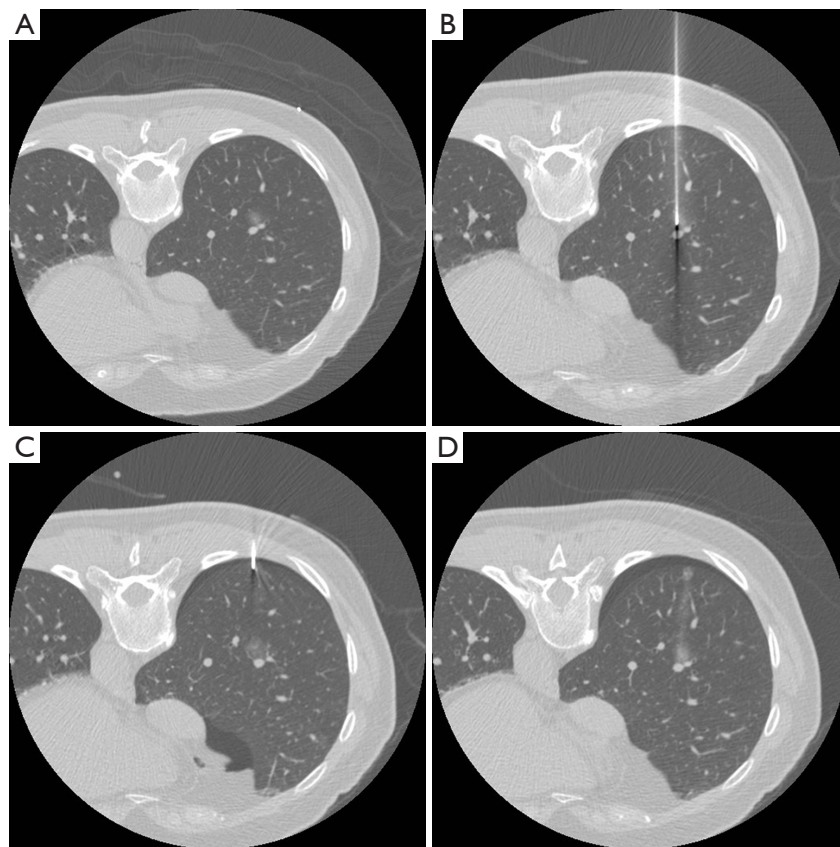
Computed tomography (CT) images of localization. (A) The patient was in supine position, and one small nodule was noted in the right lower lobe; (B) deep marks; (C) superficial marks with mild pneumothorax; (D) the nodule was fully covered by the dye, and there was no progression of pneumothorax.
